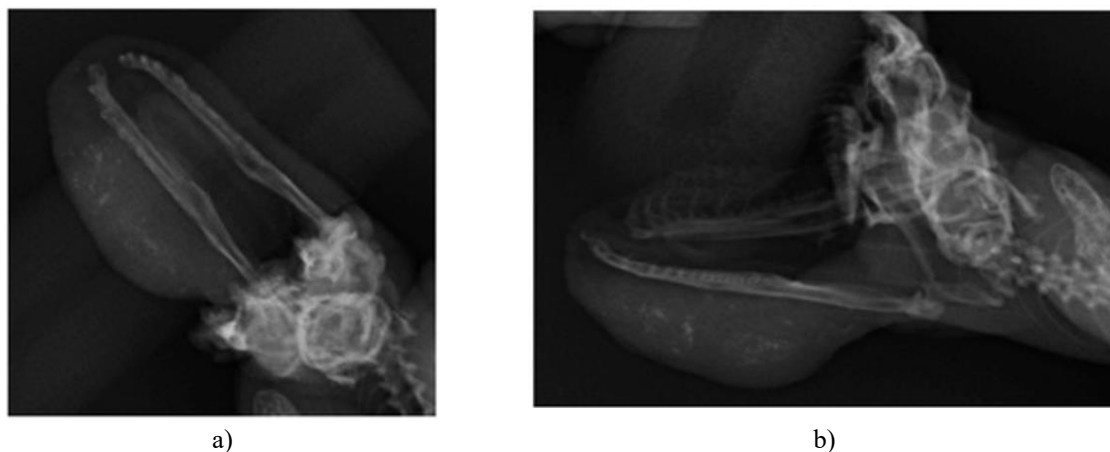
Radiographs revealed multifocal mineralization within the lesion but no mandibular invasion or lung metastasis.
